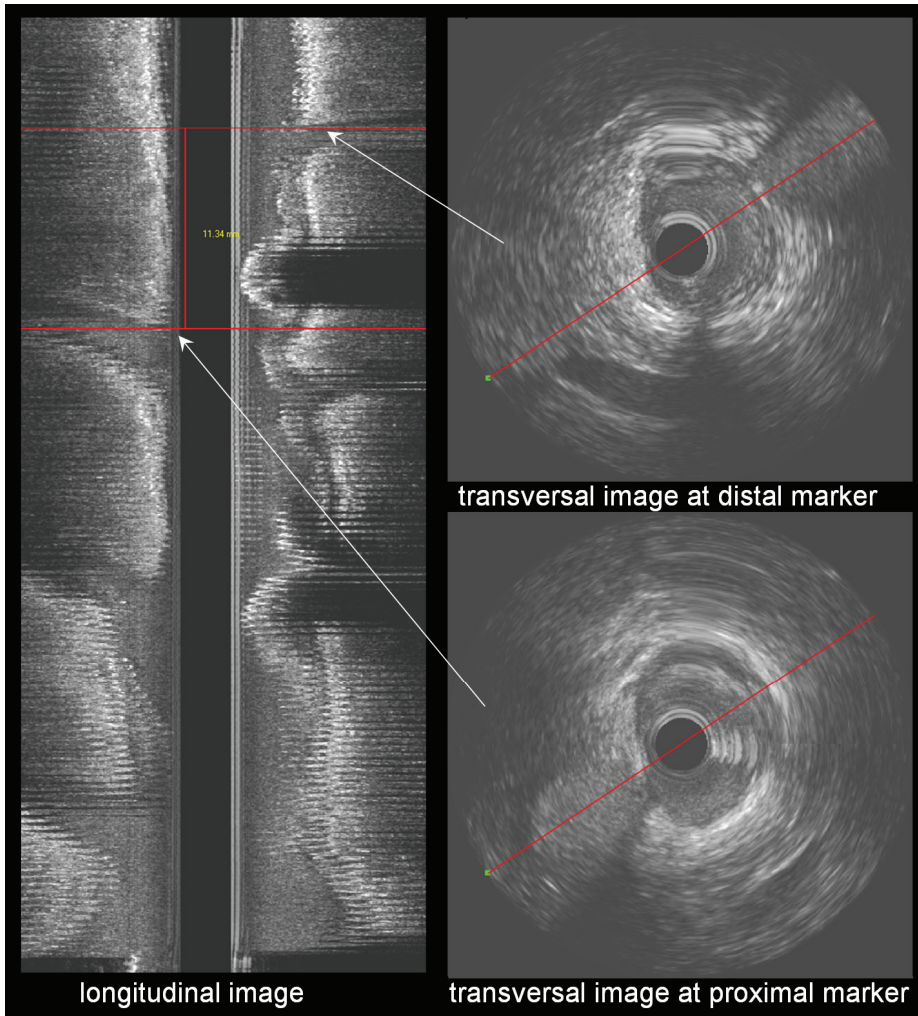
Length measurement by intravascular ultrasound. The sidebranches are visible in the longitudinal image and in the transversal images.
